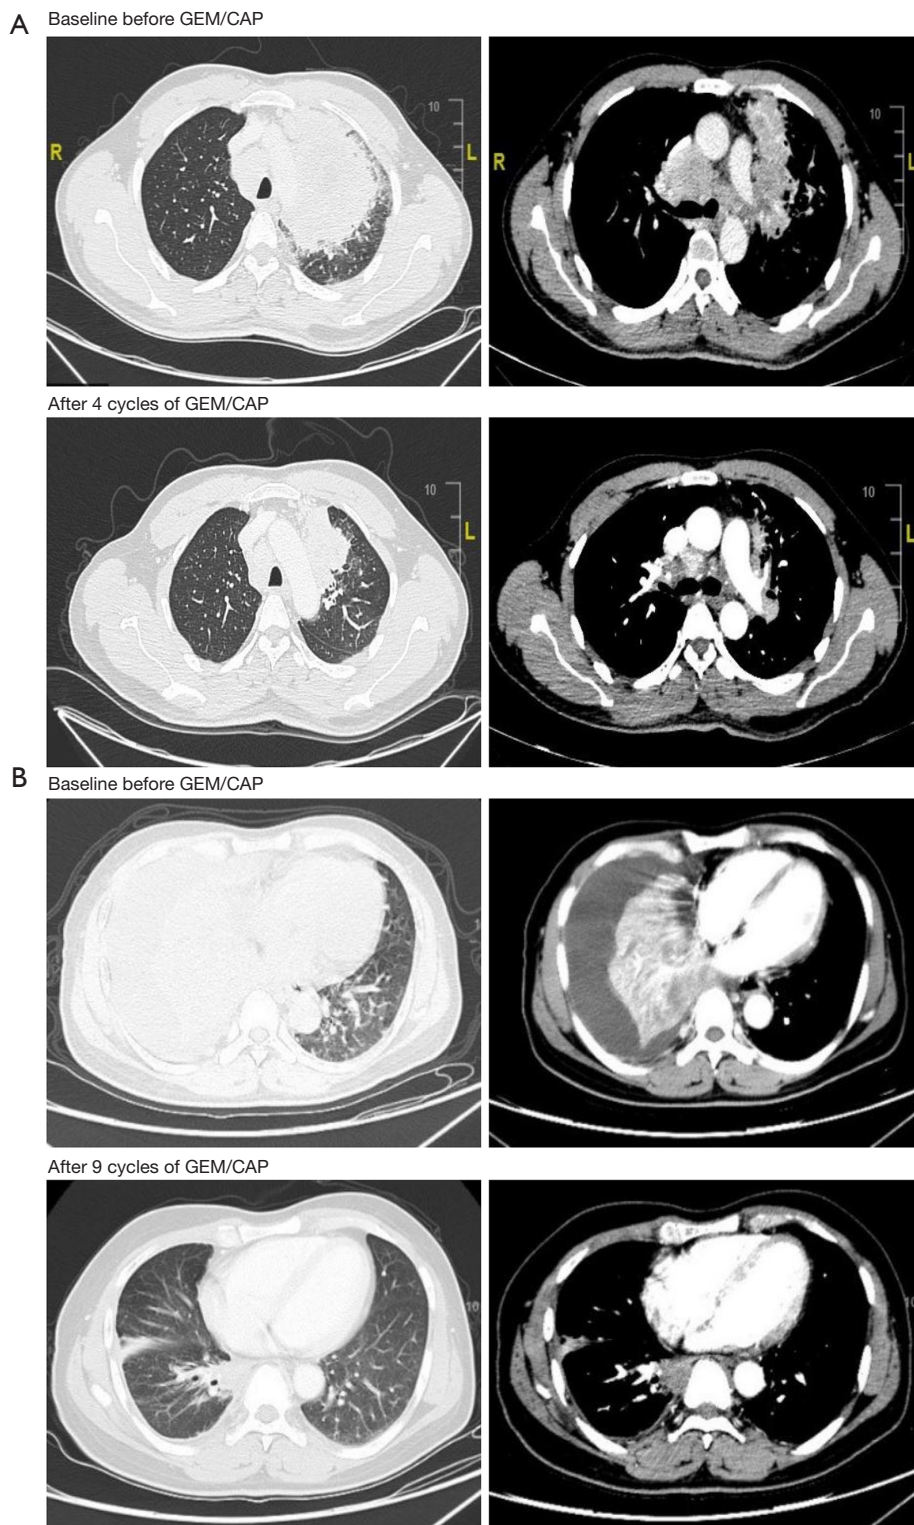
The CT images of 2 patients who accepted the treatment with GEM/CAP. A 43-year-old man with left PLELC achieved the best response of PR after 4 cycles of GEM/CAP (A). A 62-year-old man with right PLELC had the best response of PR after 9 cycles of GEM/CAP (B). GEM/CAP, gemcitabine plus capecitabine; CT, computed tomography; PLELC, primary pulmonary lymphoepithelioma-like carcinoma; PR, partial response.
